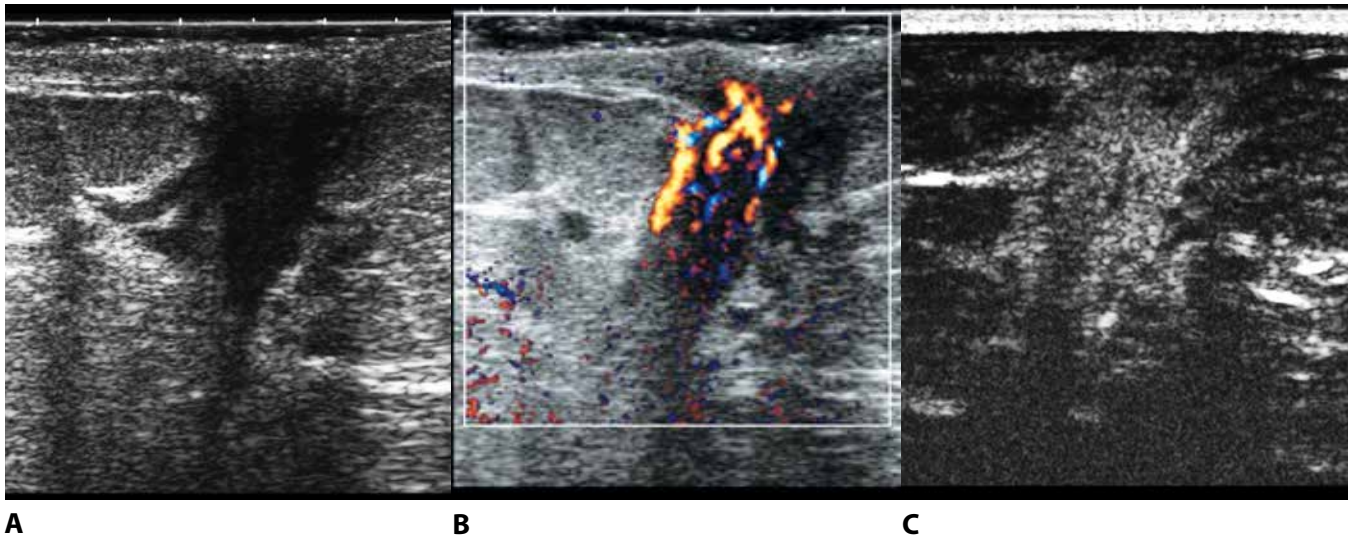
SKIN CHANGES: SKIN RETRACTION and SKIN THICKENING. There is SKIN RETRACTION and SKIN THICKENING above a small hypoechoic invasive ductal carcinoma as seen on a gray scale image (*a*), as well as with color Doppler (*b*) that shows hypervascularity of the tumor, and perfusion imaging (*c*) after US contrast medium injection, at which the tumor appears hyperechoic.
